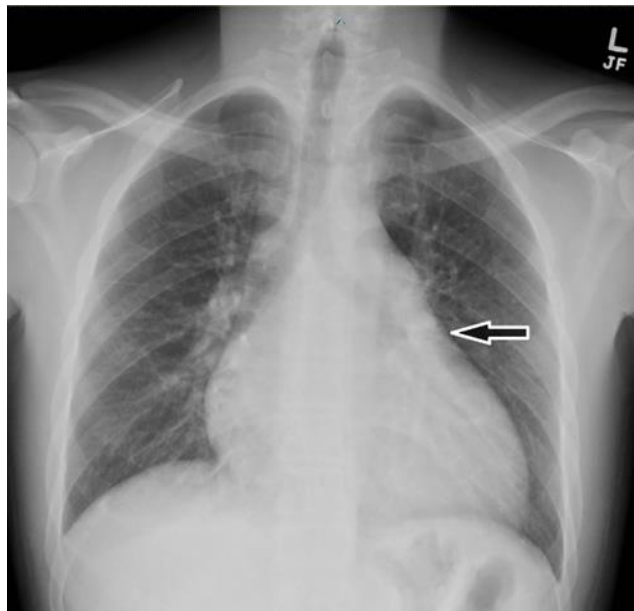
Chest X-ray showing straightening (mitralization) of the left heart border.
